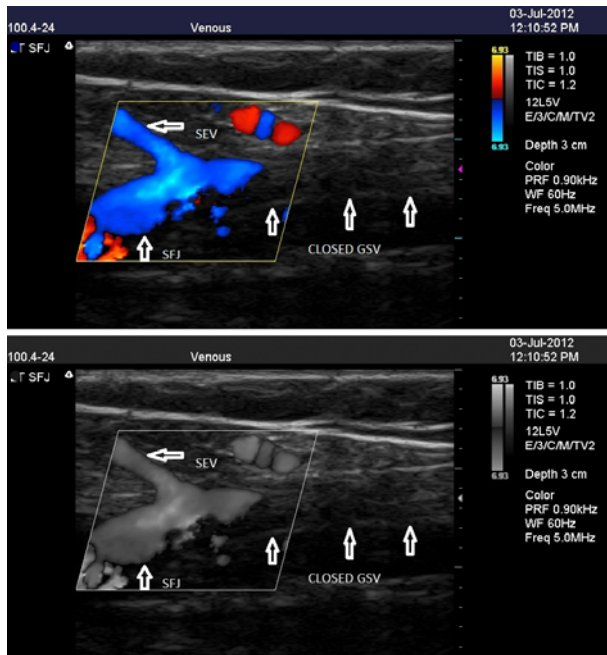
Closure of the GSV at the SFJ. Ultrasound image after one year. GSV, great saphenous vein; SFJ, saphenofemoral junction; SEV, superior epigastric vein
